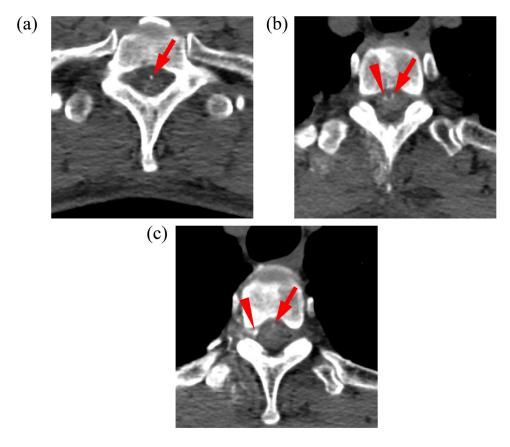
CT during intercostobronchial trunk arteriography. (A) A dot (arrow) enhancement continues craniocaudally on the anterior midline surface of the spinal cord considered to be an anterior spinal artery. (B) Another dot enhancement (arrowhead) concurs to the anterior spinal artery on the right anterior oblique surface of the spinal cord considered to be an anterior radiculomedullary artery. (C) The anterior radiculomedullary artery continues to the intervertebral foramen and concurs to an intercostal artery.
